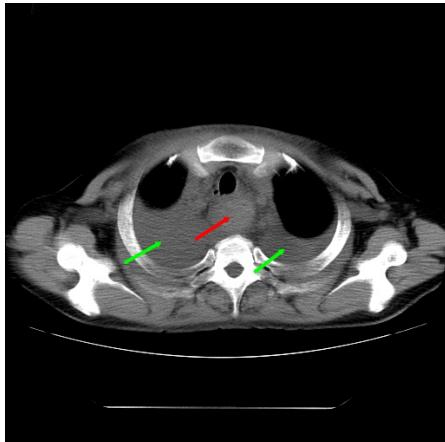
Computed tomography revealed a low-density mass in the cervical-mediastina (red arrow) and retropleural (green arrows) areas.
